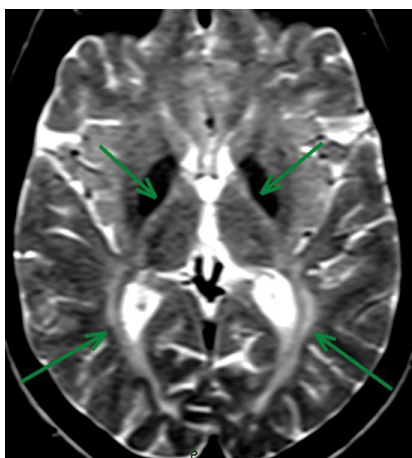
Patient with fatty acid hydroxylase-associated neurodegeneration (FAHN). Brain MRI shows bilateral globus pallidus hypointense signal, characterizing iron accumulation, and confluent periventricular white matter hyperintense signal.
